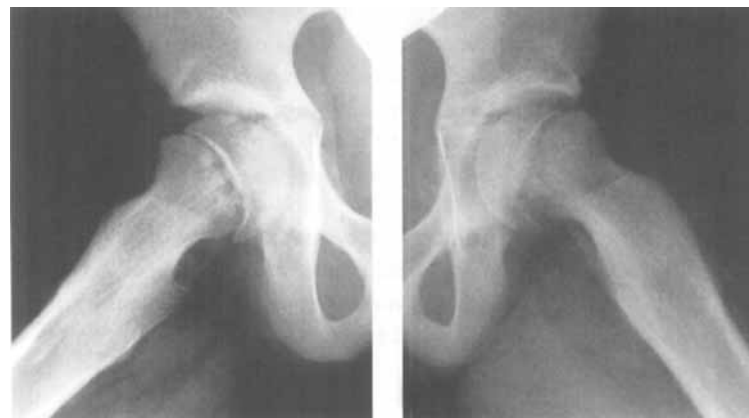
Axial radiograph of slipped capital femoral epiphysis of the right hip 3 months after removal of the wires at the age of 10 years
